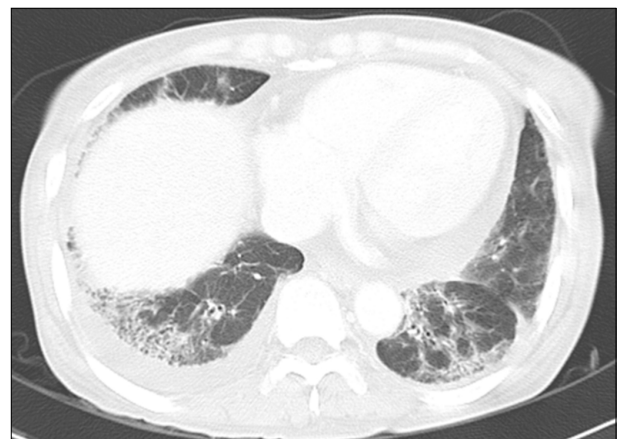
Chest computed tomography. Interstitial pneumonitis and bilateral pleural effusion.
